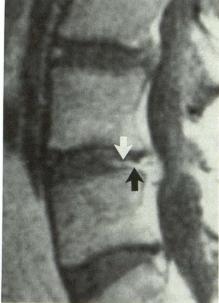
Contrast-enhanced MR images of lumbar intervertebral disk in 51-year-old woman 8 months after laminectomy and diskectomy.
